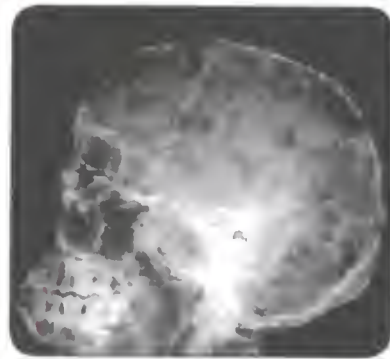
Plain X-ray skull. Note the characteristic salt-pepper appearance of the skull bone
